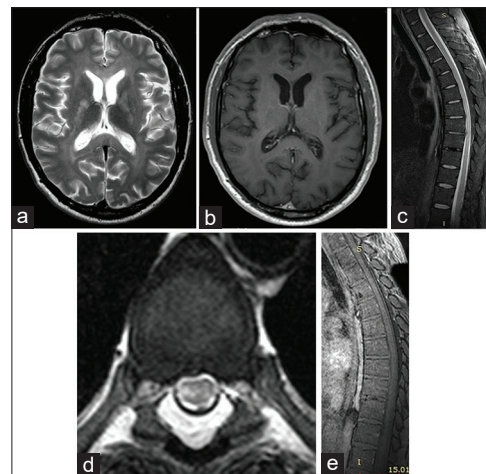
Axial T2-weighted image shows diffuse, symmetric, periventricular leukopathy sparing the subcortical fibers (a), without mass effect and contrast enhancement (b). T2-weighted image of the spine demonstrate bilateral dorsolateral column high T2 signal at the level of Th6–Th9 vertebral segments (c and d). No associated cord enlargement. Note focal protrusions at the Th7–8 and Th8–9 levels with mild cord compression (c). There was no evidence of abnormal enhancement in the postcontrast study (e)
